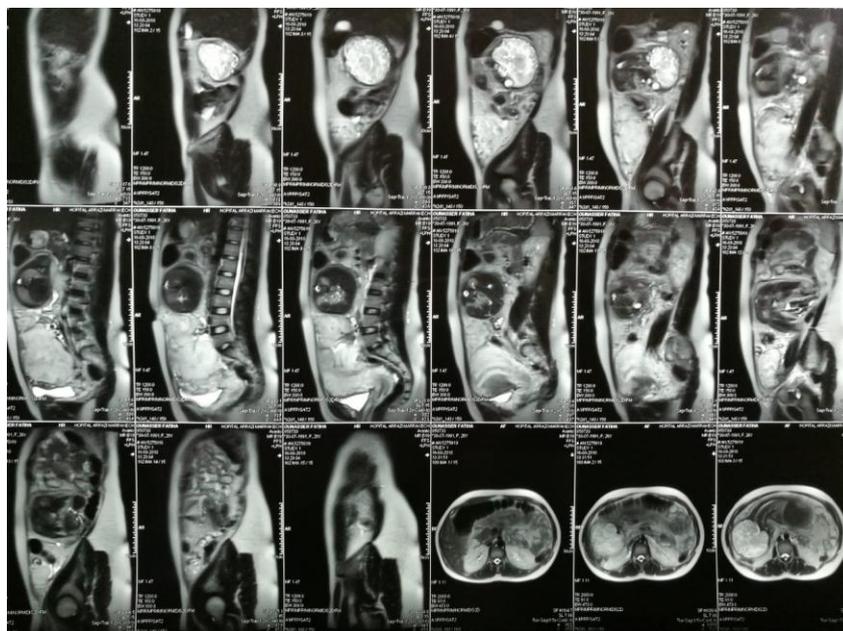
MRI showing the abdominal location of the fetal body with intact uterus and adnexals, placenta adhering to the bladder and attached to the serosa of the uterine fundus
